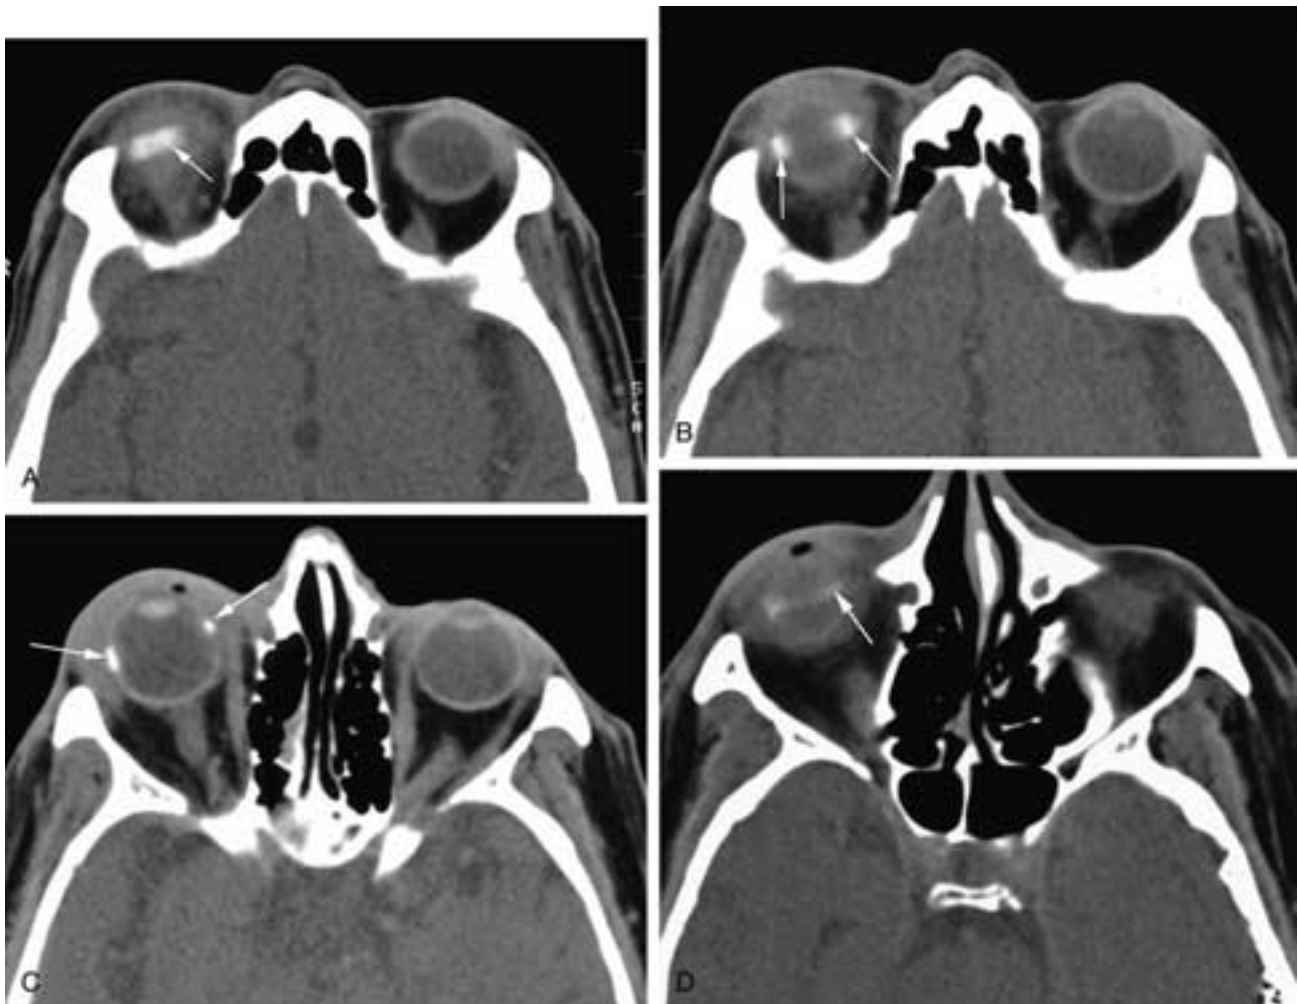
Scleral buckle in retinal detachment. A to D, Axial CT images showing the linear radial density encircling the globe (arrows). Note that if followed on all images, the radiodensity makes a complete ring around the globe.
